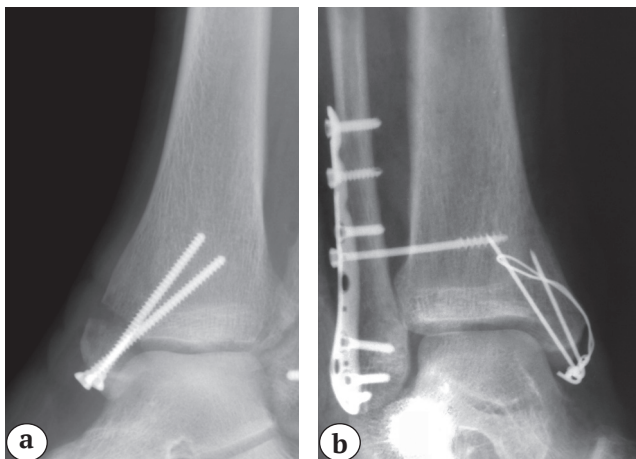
X-rays of the medial ankle after osteosynthesis with a metal screw:
